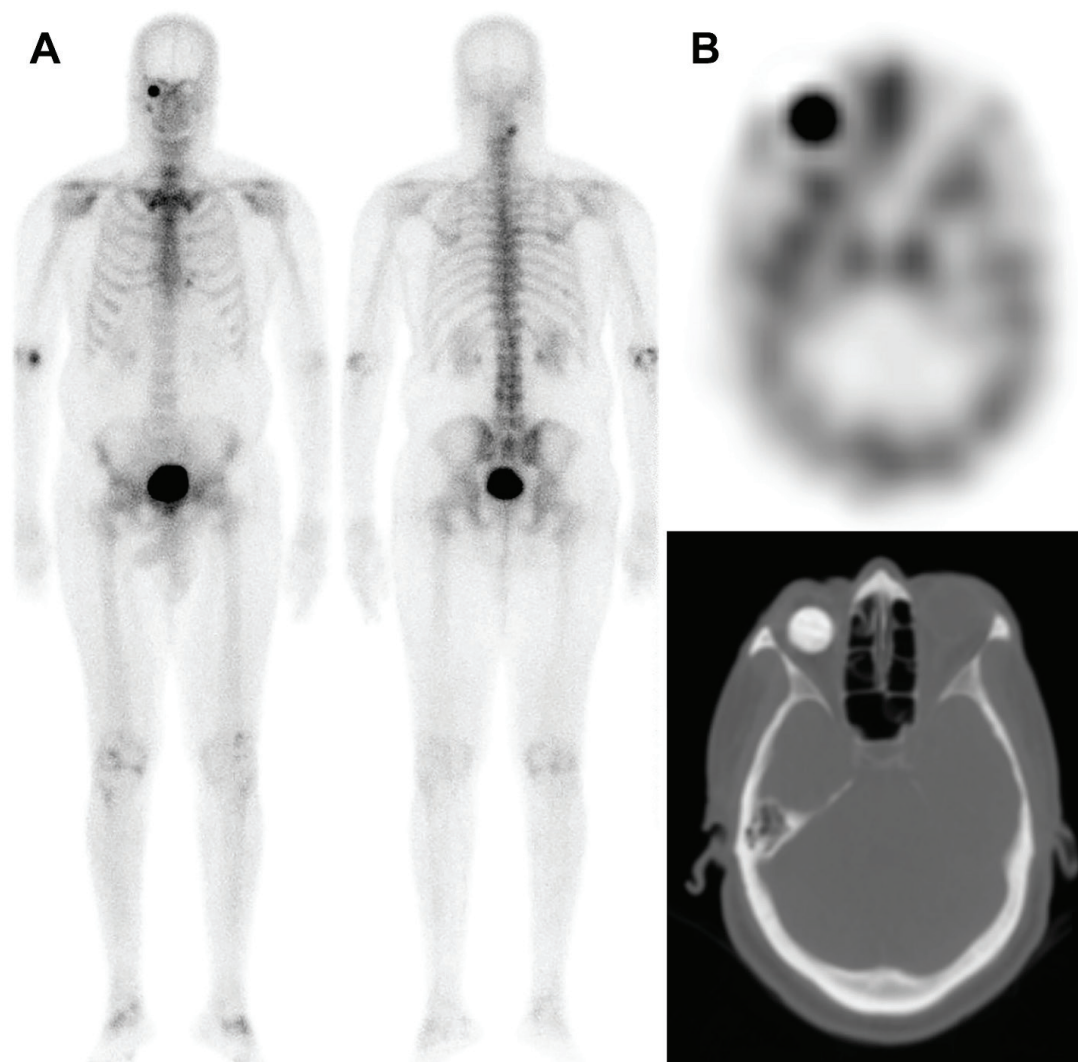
A 74-year-old man recently diagnosed with high-risk prostate cancer with high serum prostate specific antigen was referred to nuclear medicine for a technetium-99m-methylene diphosphonate (Tc-99m MDP) bone scan. As per institutional protocol, whole-body blood pool images were acquired, which were unremarkable (not shown). A) On delayed three-hour planar images, an unexpected round focus of intense uptake was found overlying the right orbit. B) Selected axial slice of Tc-99m MDP single-photon emission computed tomography/computed tomography showing intense uptake throughout a right hydroxyapatite ocular prosthesis. The hydroxyapatite nature of the ocular implant can be recognized by its bone-like density and its accumulation of bone scan agent. Review of the patient's history revealed right eye evisceration 20 years prior secondary to a complication of cataract surgery, consistent with the findings.
